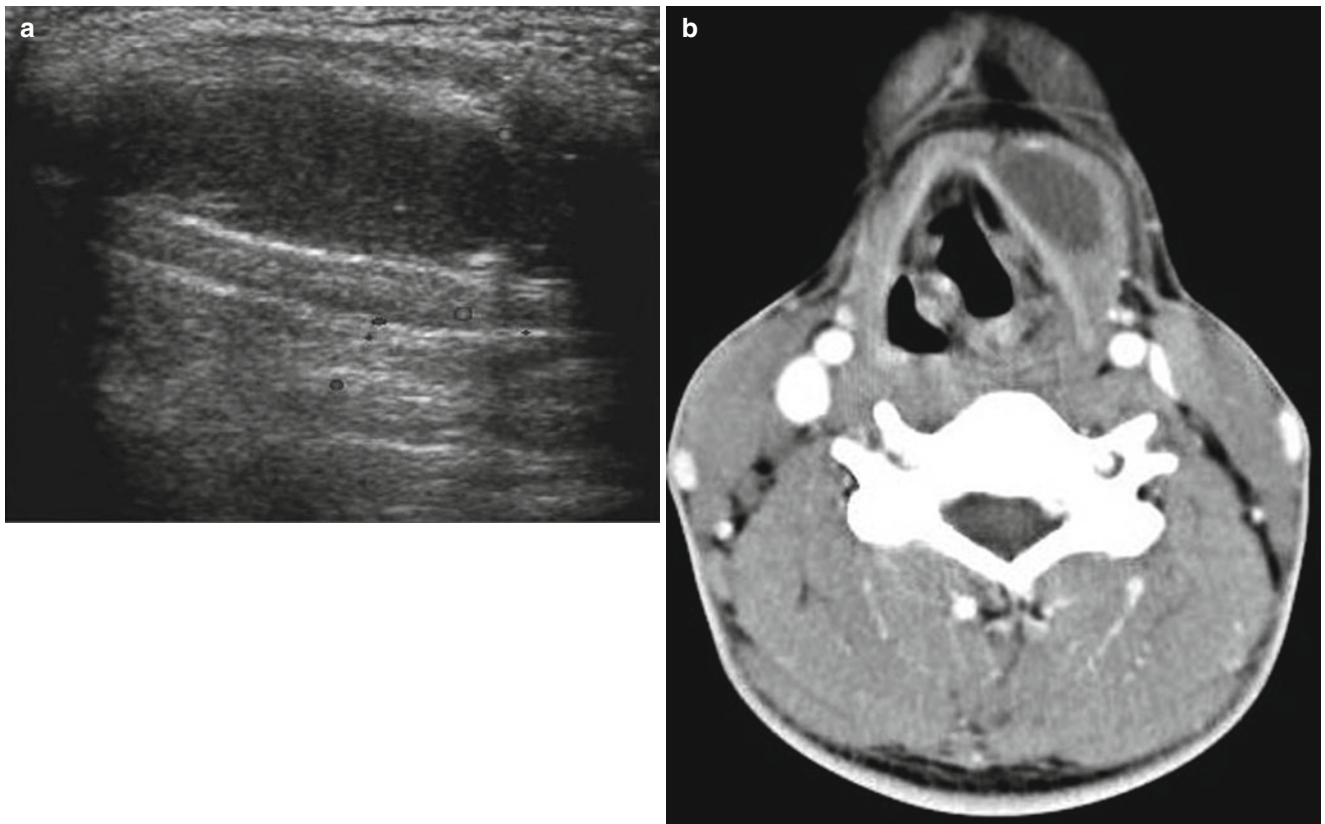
Infrahyoid thyroglossal duct cyst in a 15-year-old boy. (a) US shows a hypoechoic cystic mass embedded in the left strap muscle. (b) Contrast-enhanced axial CT scan shows a well-defined unilocular, thin-walled cyst embedded in the left strap muscle
